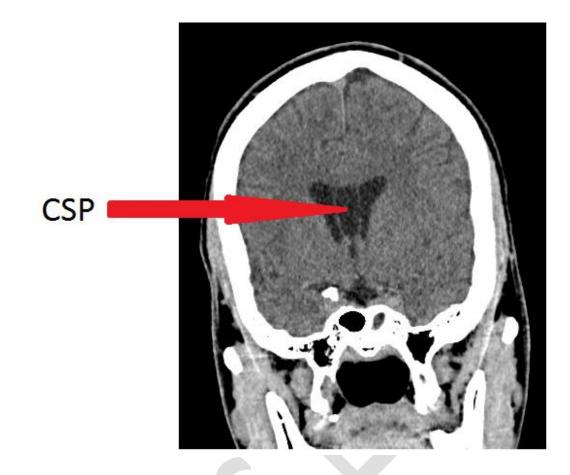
Enlarged CSP (coronal slice of a pre-contrast CT scan of the brain at the level of the frontal horns of the lateral ventricles)
